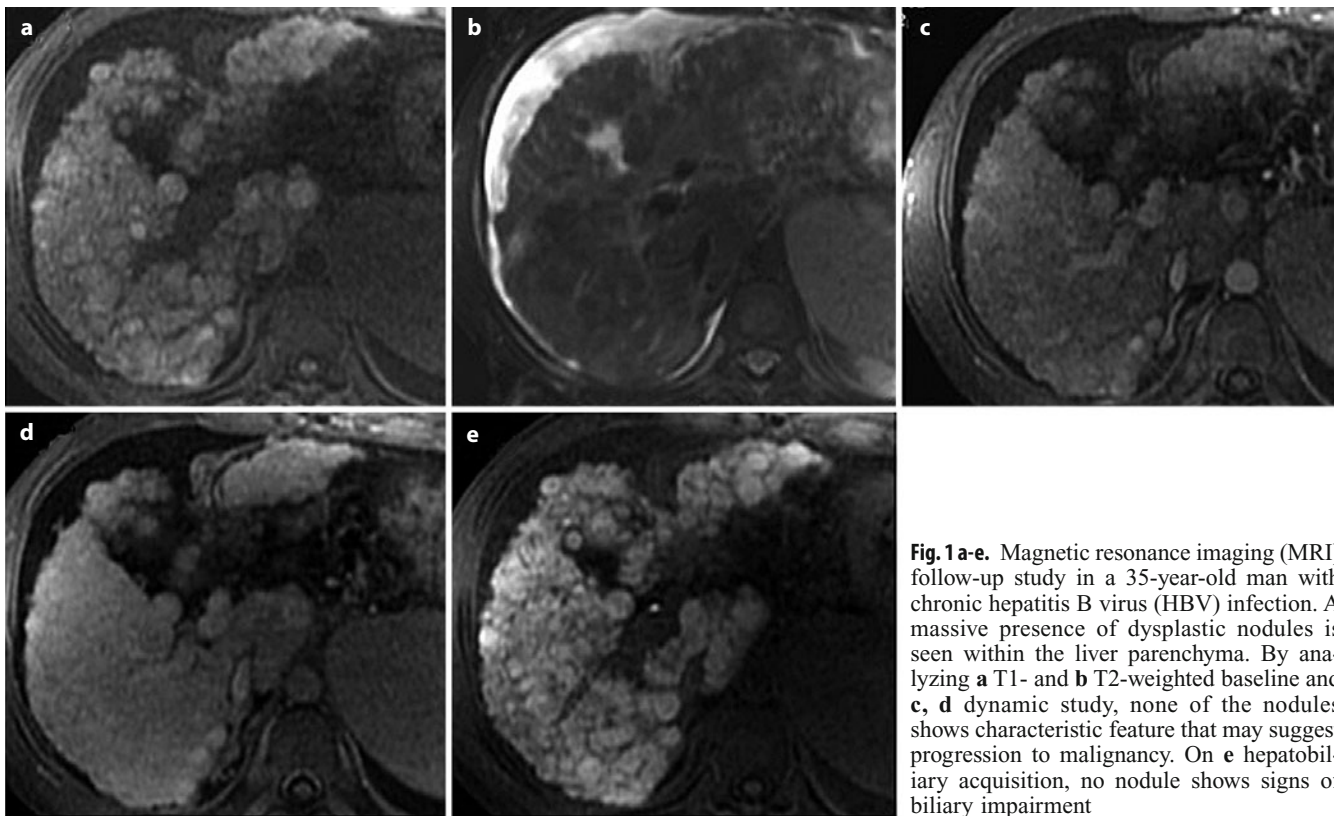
a-e. Magnetic resonance imaging (MRI) follow-up study in a 35-year-old man with chronic hepatitis B virus (HBV) infection. A massive presence of dysplastic nodules is seen within the liver parenchyma. By analyzing a T1- and b T2-weighted baseline and c, d dynamic study, none of the nodules shows characteristic feature that may suggest progression to malignancy. On e hepatobiliary acquisition, no nodule shows signs of biliary impairment
